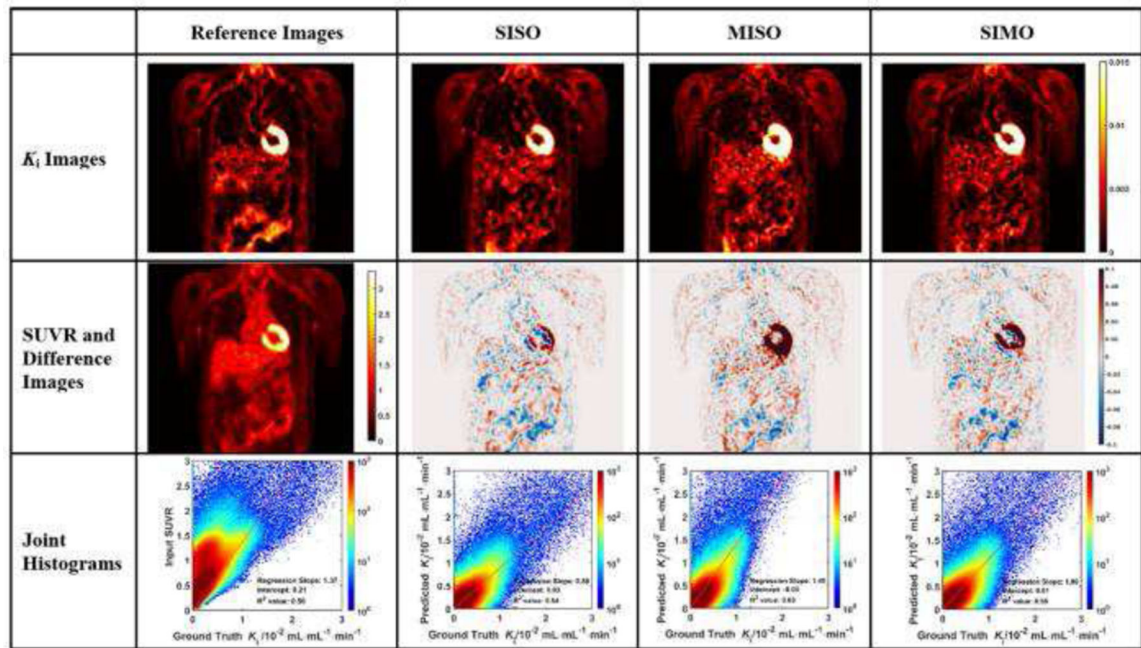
Evaluation analysis of sample subject #1 including the synthetic and reference K_i images, corresponding difference images, SUVR input image, and the joint histograms. In each joint histogram, the regression line was represented by the red straight line, with labels of regression slope, intercept and R^2 value.
